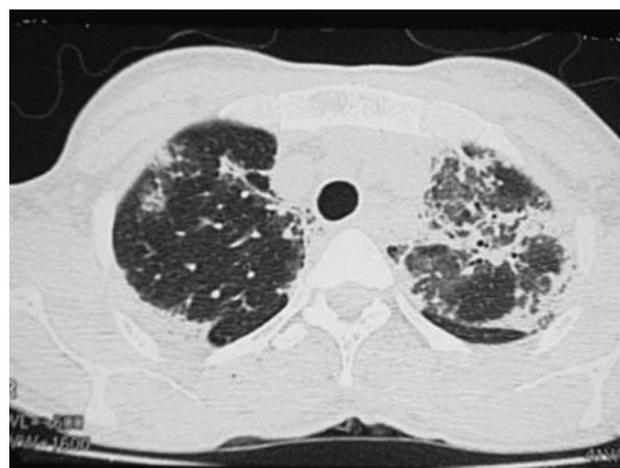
CT scan of the patient’s chest, which demonstrates bilateral pulmonary fibrosis 11 days after exposure to paraquat (I.B. Gawarammana, N.A. Buckley, 2011) [8].
